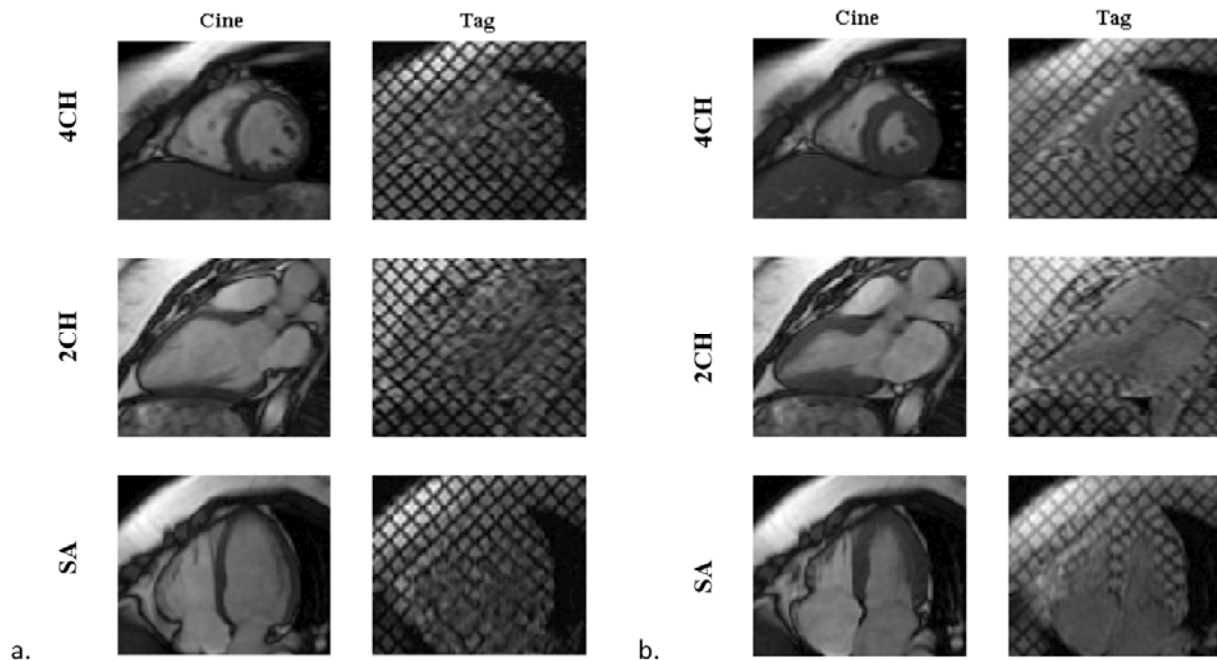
Cine and corresponding tagged MR images at ED (a) and ES (b) [12].
